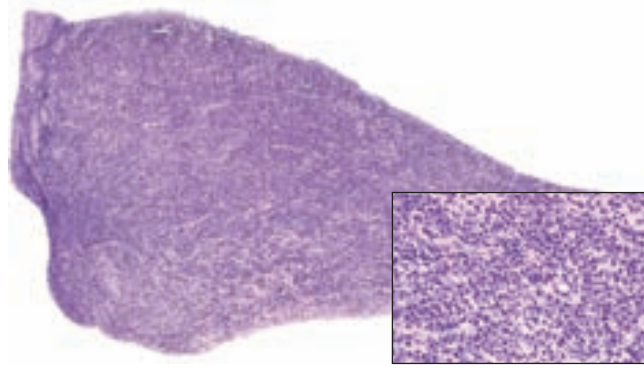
Periapical granuloma with sheets of plasma cells (inset).
